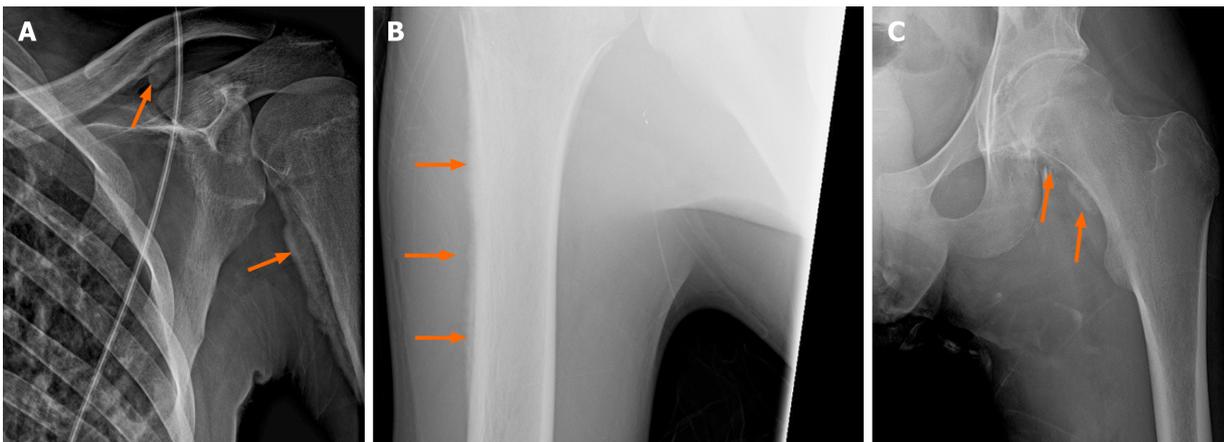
X-ray of bones showed evidence of skeletal fluorosis. A: Periosteal elevation (arrows) on the left clavicle and proximal left humerus; B: Fluffy periostitis (arrows) on the right humerus; and C: Periosteal reaction (arrows) on the proximal left femur.
